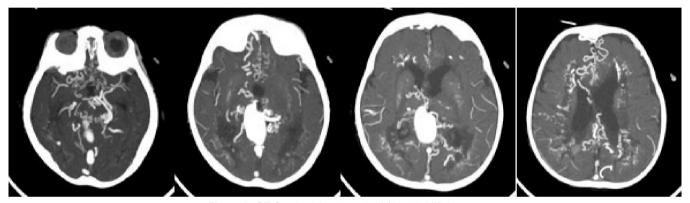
CT Cerebral Angiography (a) Axial- MIP Images
